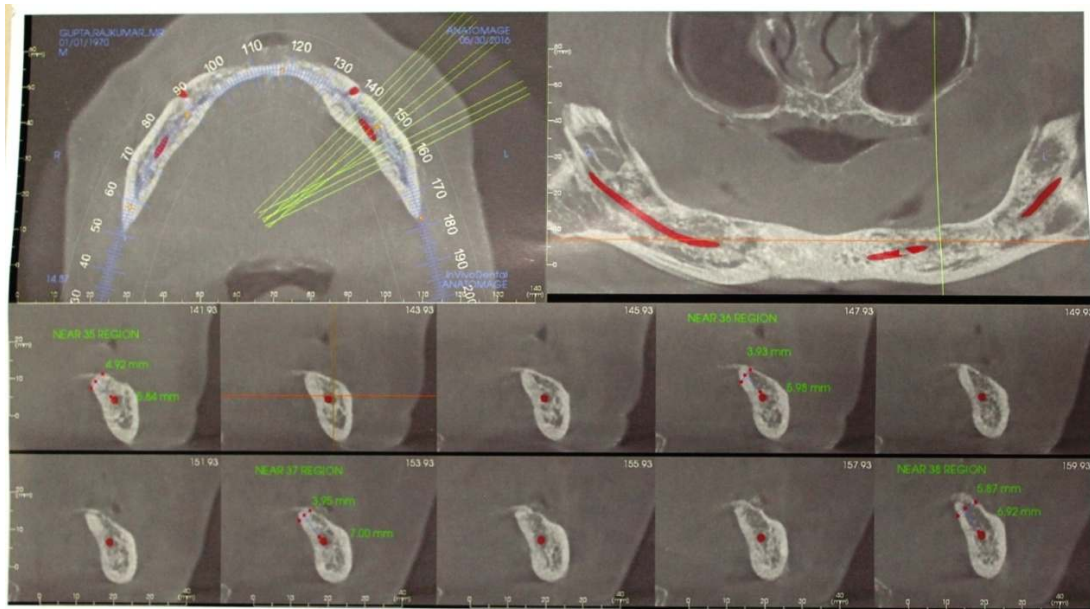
CT SCAN Showing Reformatted Images, complete maxillary and mandibular region, slices and measurements of bone. Red dots and dark red line showing mandibular canal, nerve and foramina with measurement line
